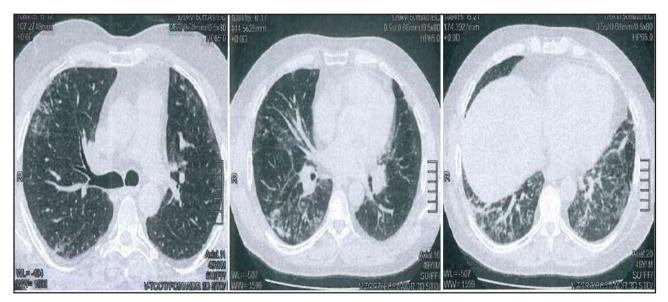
Chest CT upon admission shows diffuse ground-glass opacities of the middle lobe and the two lower lobes.
